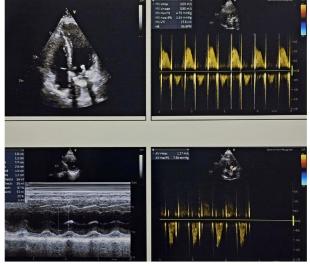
Postoperative color Doppler echocardiogram showing well-functioning mechanical mitral valve
